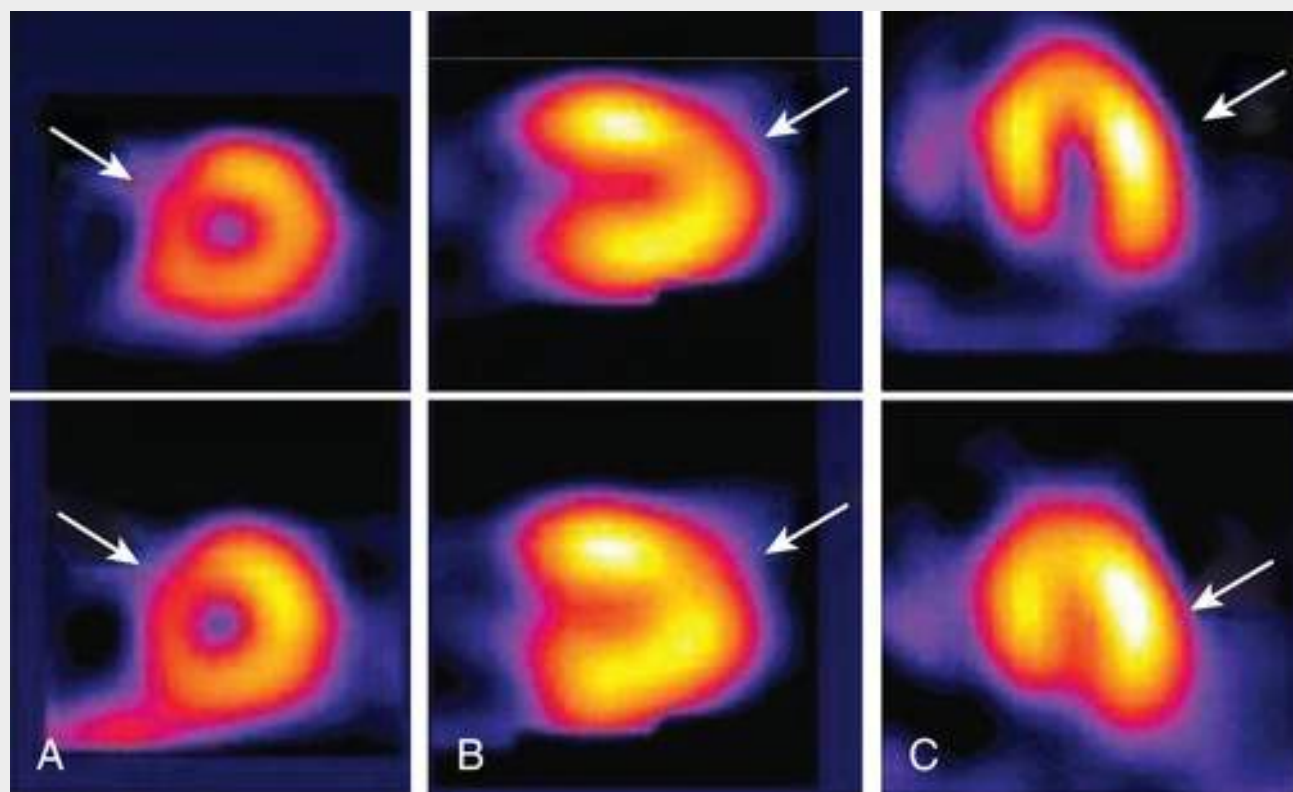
Normal variations in SPECT perfusion imaging. A, Normal “dropout” of the basal septum (arrows), which would be seen in the most basal short-axis tomograms. B, Normal apical thinning (arrows). C, The lateral wall often is slightly “hotter” than the septum, another normal variation.
